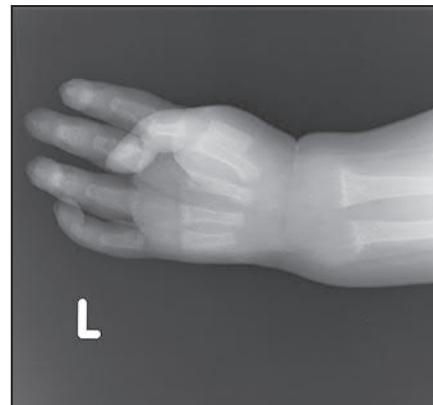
X-ray of the child's wrist showing rickets. The ends of the radius and ulna are expanded, rarefied, and cup-shaped, and the bones are poorly mineralized. (Courtesy of Paul Arundel.)
